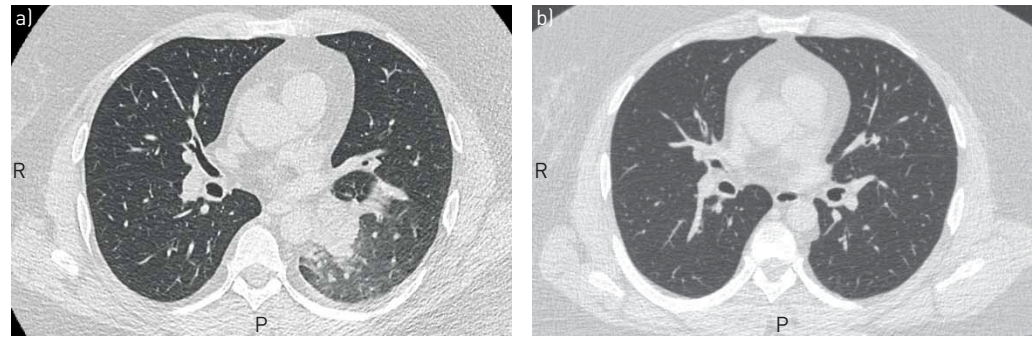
Chest computed tomography scans in the axial plane the day after bronchial thermoplasty in a) the left lower lobe and b) 1 week later showing the rapid disappearance of opacities.
